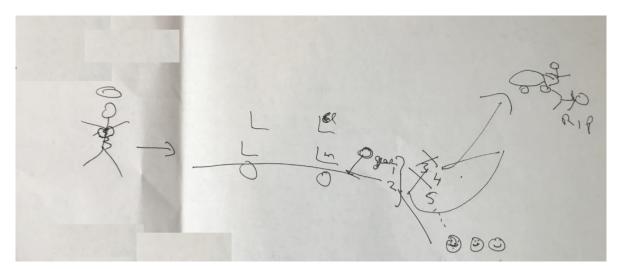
The Bus - A Radiographer's metaphor for the CT service.
